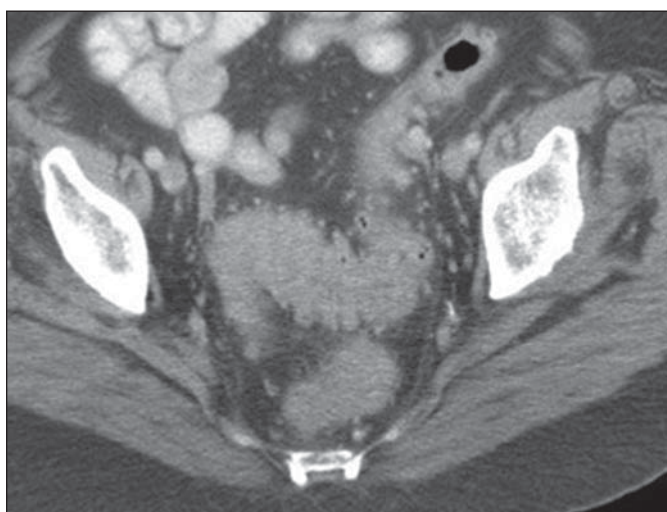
71-year-old woman receiving ipilimumab for treatment of metastatic melanoma. Axial CT image of pelvis shows mural thickening of sigmoid colon with adjacent fat stranding and mesenteric hypervascularity. Colonic biopsy revealed moderate-to-severe active inflammation, consistent with ipilimumab-induced colitis.
